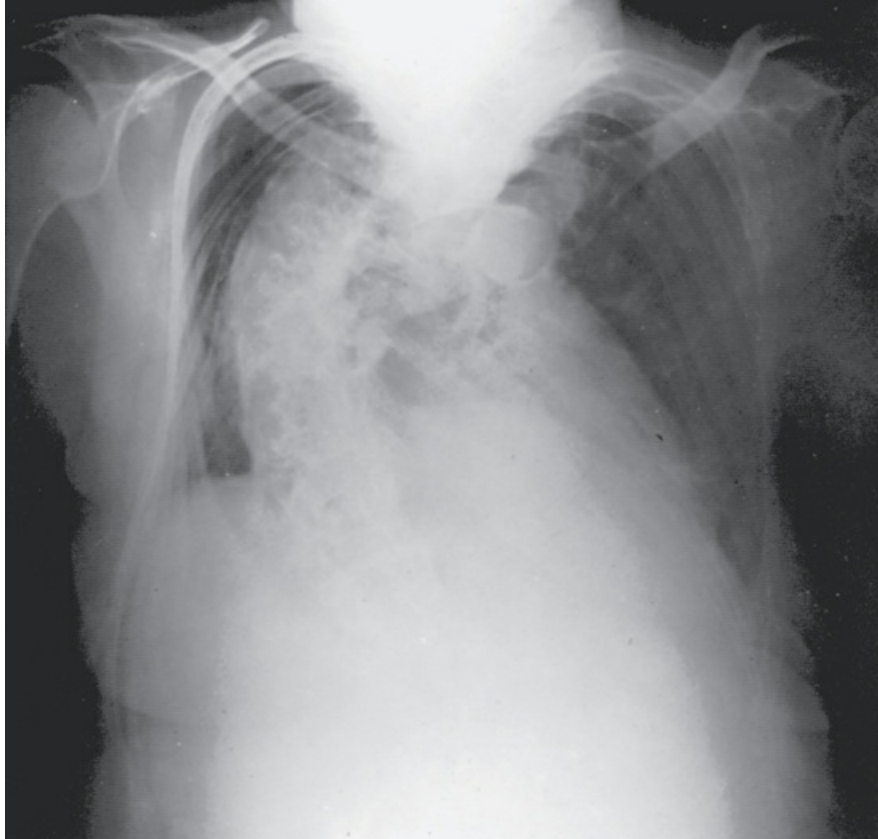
Chest radiograph of patient with severe kyphoscoliosis. Note marked spinal curvature and chest wall distortion.
